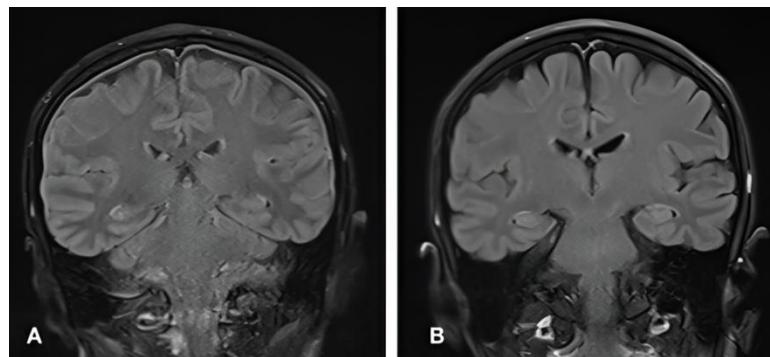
Leptomeningeal thickening on MRI. A.: Initial diagnosis, B.: After one course of therapy
